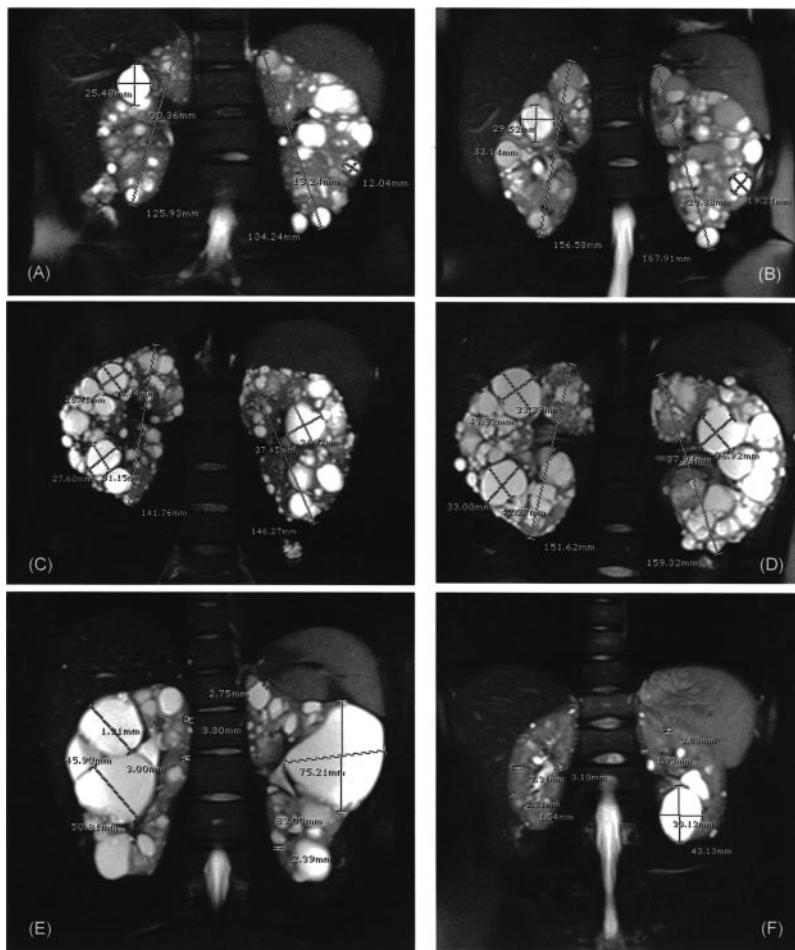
Representative T2-weighted coronal MRI images from study participants. Interval change in female subject at (A) 15 and (B) 19 years of age. Interval change in male subject with very early-onset ADPKD at (C) 16 and (D) 21 years of age. MRI images demonstrating range of cyst sizes in (E) female subject at 18 years of age and (F) in a different female subject at 10 years of age. The smallest cyst size that could be documented was approximately 2 mm.
